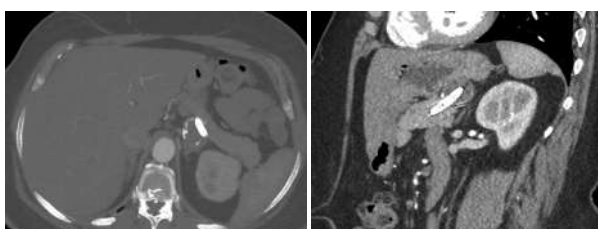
Follow-up CTA without endoleaks
